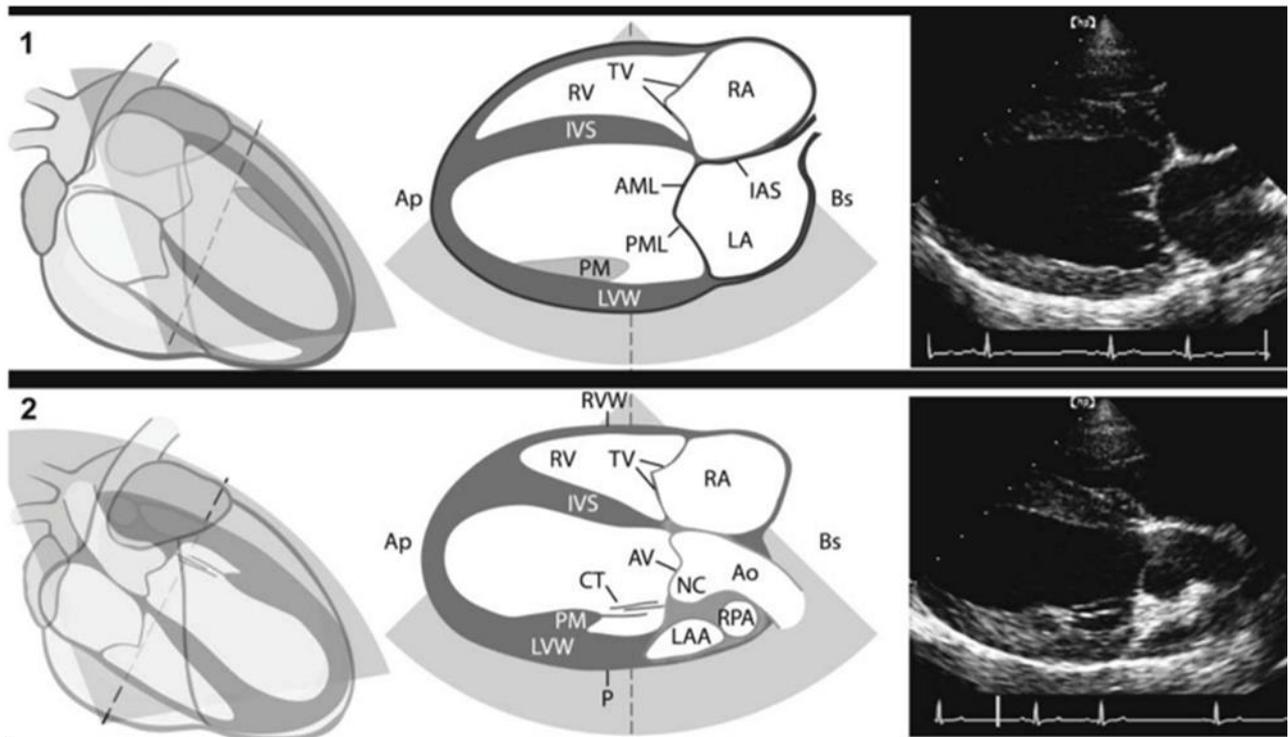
(Top) The left ventricular axis can be conceptualized as an imaginary line extending from the cardiac apex to the base of the left ventricular lumen (LV; left ventricle, RV; right ventricle, Ao; aorta, PT; pulmonary truncus, RVOT; right ventricular outflow tract.) (Bottom) (1) Orienting the transducer to parallel this axis with the scanning plane gives the right parasternal four-chamber view, note that the central transducer beam is perpendicular to the left ventricular long axis. (2) Slight cranial angulation and counterclockwise twisting of the transducer, gives the right parasternal five-chamber view
